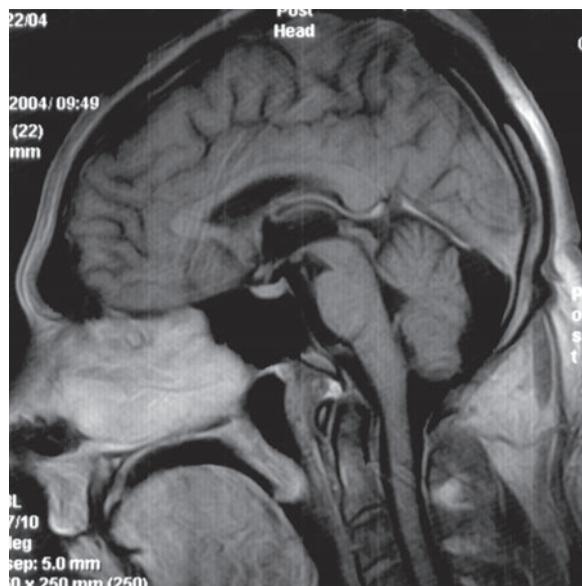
Mega Cisterna Magna (MCM). MRI sagittal T1-weighted image shows small fluid collection localized posteriorly to the normal cerebellar vermis. The fourth ventricle and posterior fossa present normal. There are no signs of hydrocephalus.
